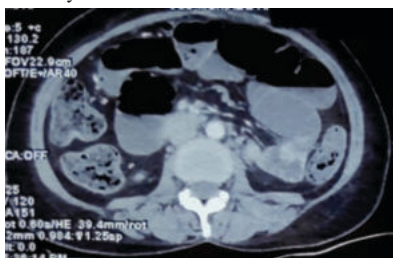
Contrast enhanced CT abdomen showing dilated fluid filled small bowel loops with distal ileal loop showing air densities within its wall
